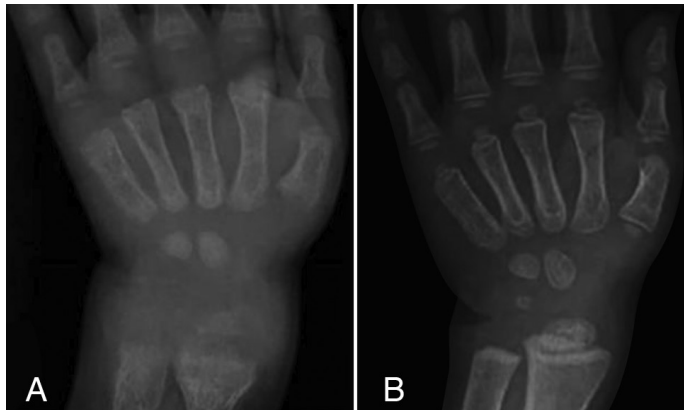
X-rays of this patient before (A) and at the 6th month of calcitriol treatment (B)
